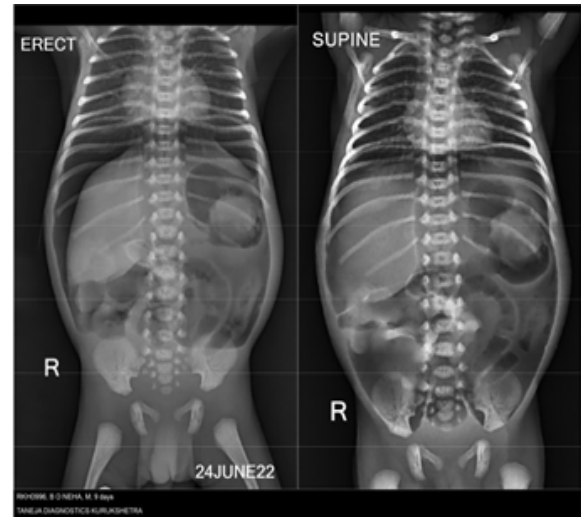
Xray abdomen on post operative day 4 showing pneumoperitoneum (anastomotic leak)
